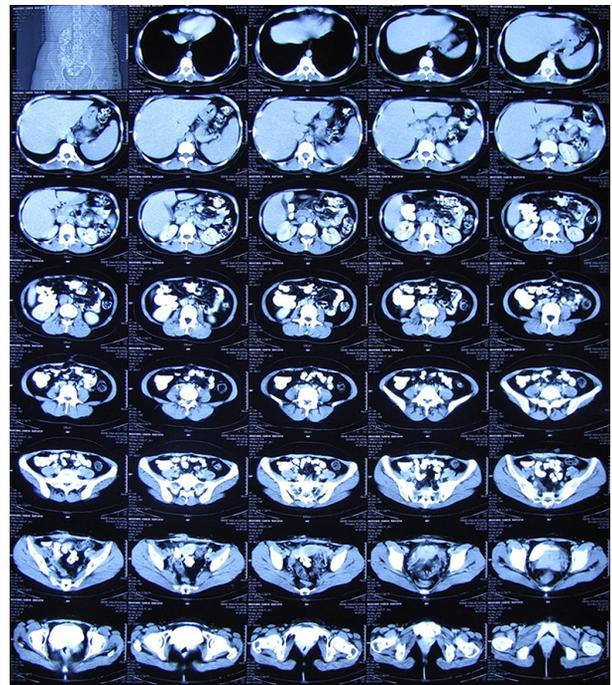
Contrast Computed Tomography (CT) Revealed That Dye Leaked Into the Uterus Via Narrow Fistula
